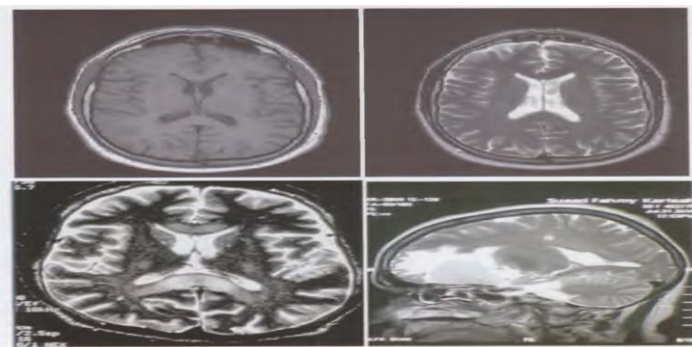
BRAIN MRI (SPOTLIGHTS IN ANAESTHESIA VOLUME 2)
